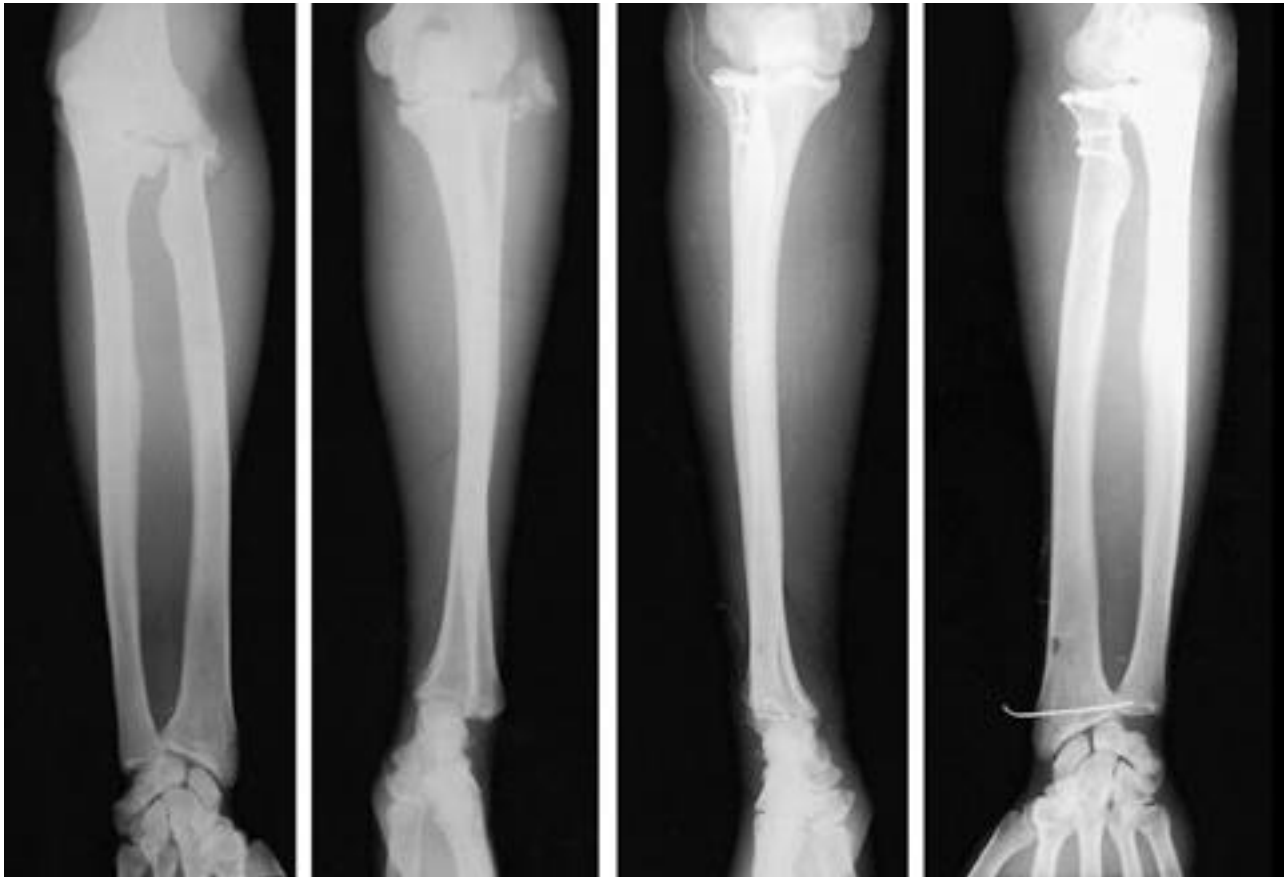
Preoperative and postoperative forearm anteroposterior and lateral radiographs of Essex-Lopresti injury and Mason type III radial head fracture after out-car traffic accident. Distal radioulnar dislocation was seen and that was reduced after Kirschner's wire fixation
